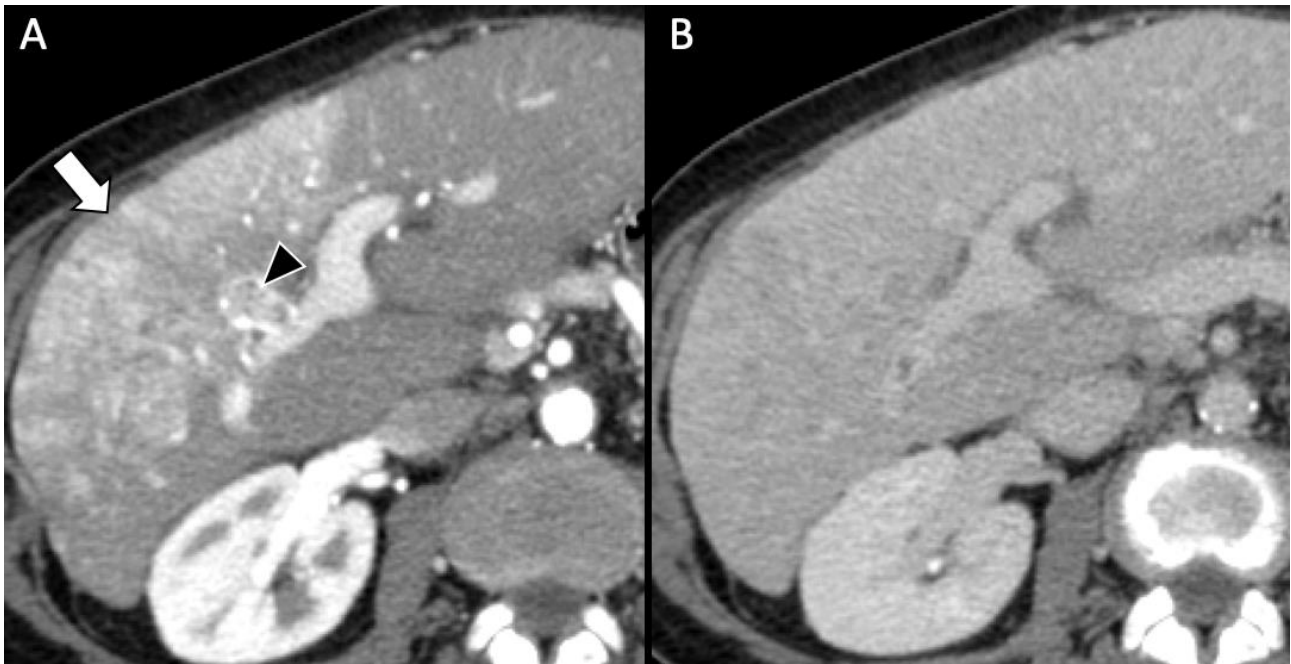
67-year-old woman with infiltrative HCC and neoplastic tumor thrombus. Axial CT image (a) on arterial phase demonstrates an enhancing tumor thrombus (arrowhead) in the right anterior portal vein branch with the “thread and streak sign”; the malignant portal vein thrombus causes expansion of the involved portal vein branch and is adjacent to an ill-defined enhancing tumor mass (arrow) (a). Notably, the marked enhancement on arterial phase is due to both HCC and perfusion abnormalities related to portal vein thrombosis, thus overestimating the entity of the tumor mass. (b) On portal venous phase only some areas demonstrate washout within the ill-defined enhancing tumor mass.
